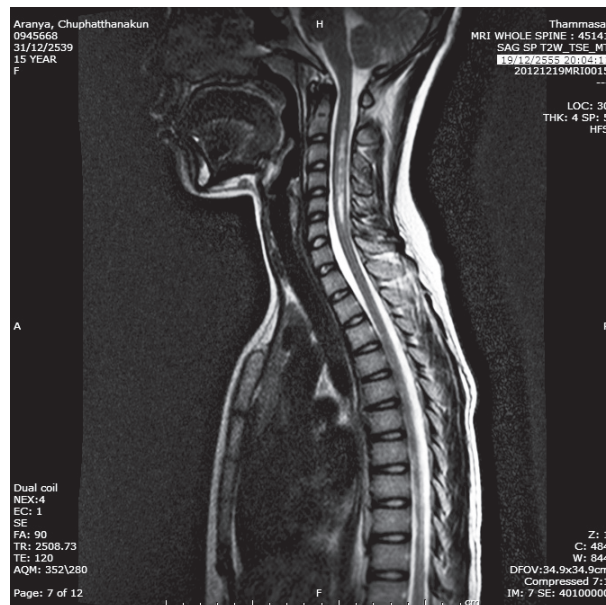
show hyperintense lesions with focal cord enlargement in cervical 2nd-6th segments in whole spine MRI.
